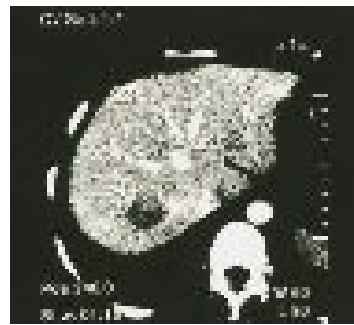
CT scanning showing a lesion with reduction of density in the posterior part of the right lobe of liver.
